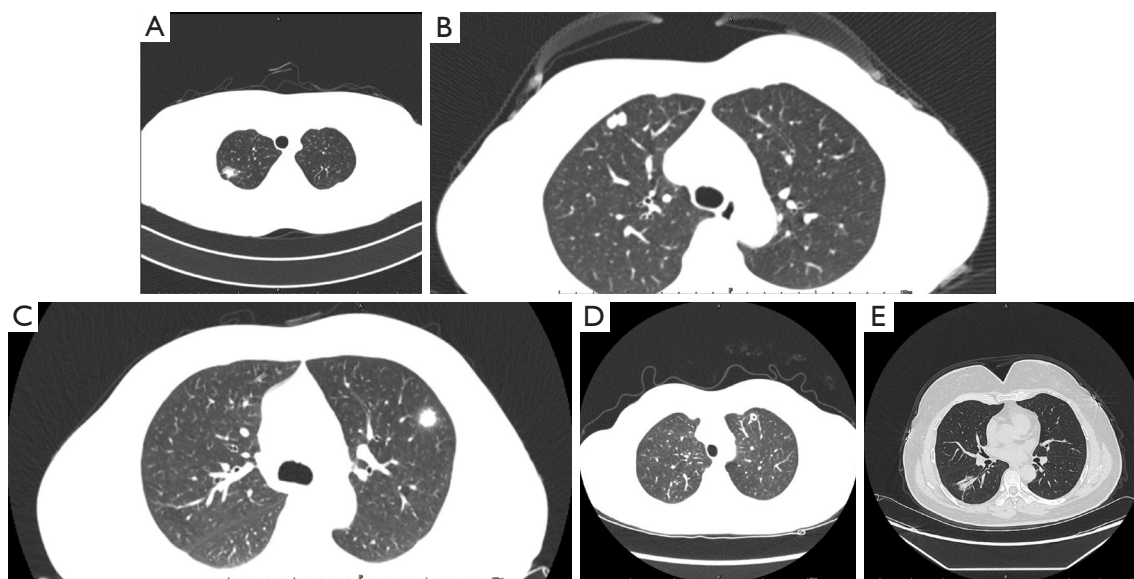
Common chest CT signs of pulmonary nodules. (A) Pleural retraction sign; (B) lobulation sign; (C) spiculation sign; (D) vacuole sign; (E) air bronchogram sign. CT, computed tomography.
